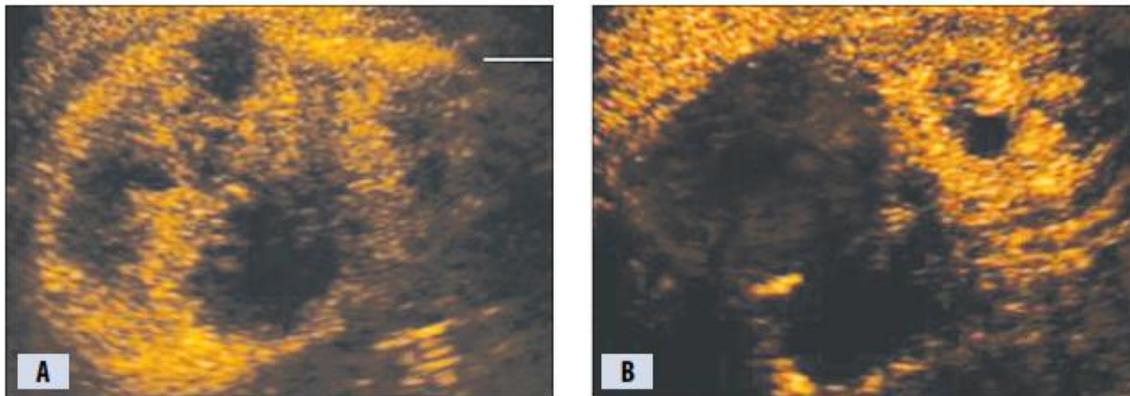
(A, B): Contrast medium - assisted ultrasound of the left renal upper pole tumor image prior - (A) and 15 - days post - chemoembolization (B), depicting the extensive lesion necrosis as non - opacified
